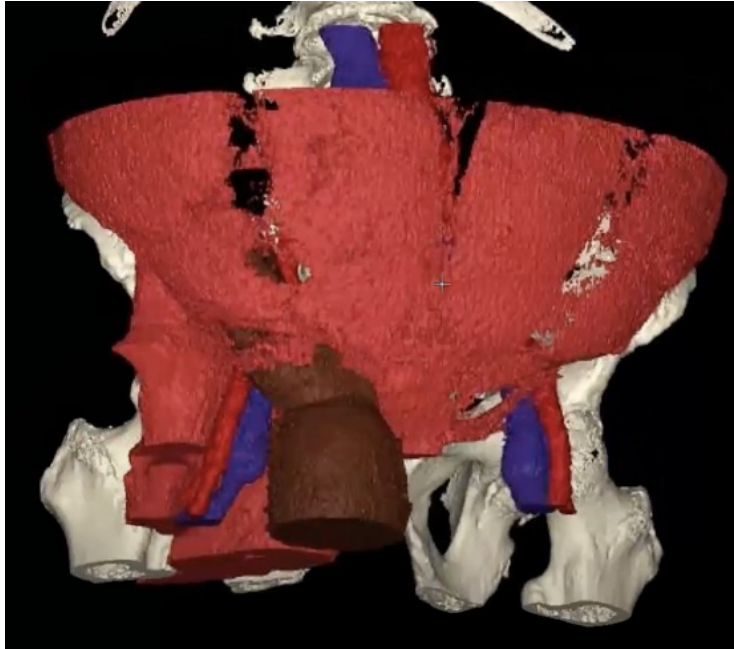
CT Helix Abdomen Simple Axial Section – Inguinal Hernia.
